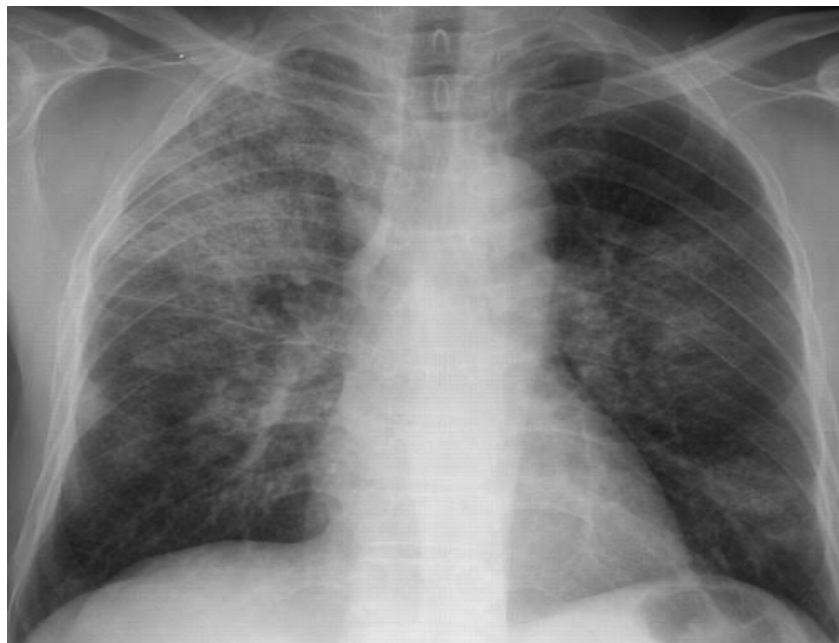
X-ray chest showing bilateral infiltration
